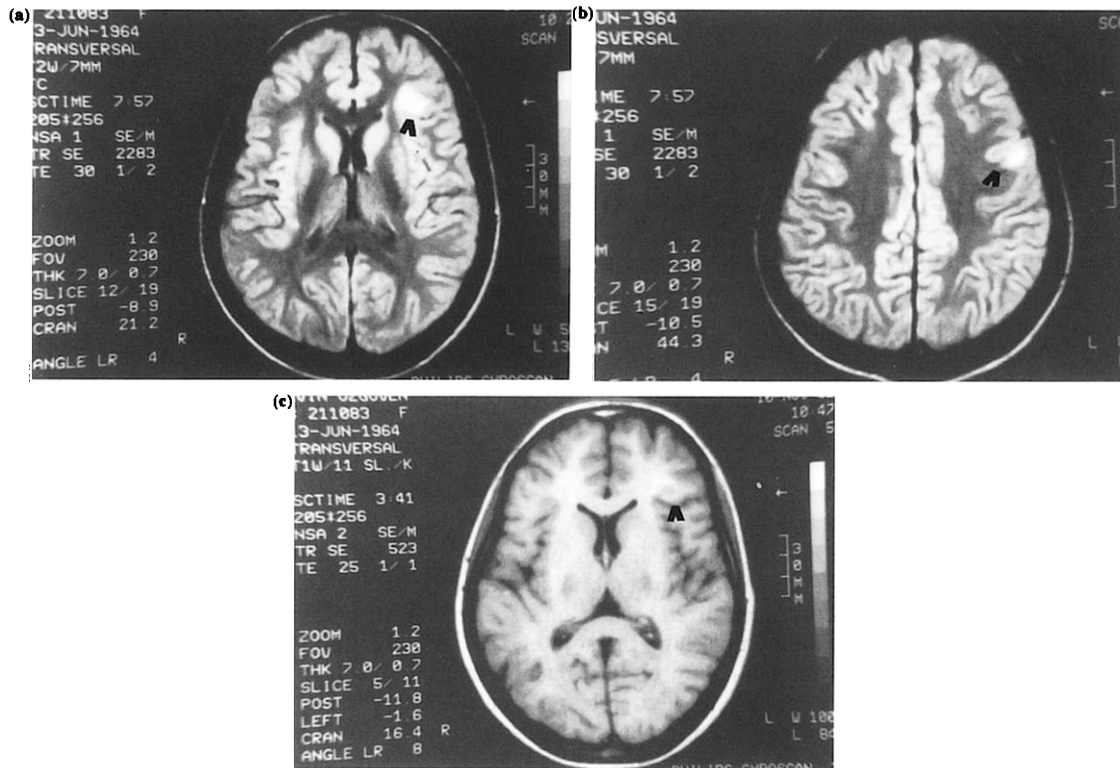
There were multiple high signal intensities appeared over the left frontal precentral corticosubcortical and paracentral cortical areas on proton density (0.5T, TR 2283, TE 30) images (a, b) which also became enhanced with gadolinium on T1-weighted (0.5T, TR 523, TE 25) images (c).
